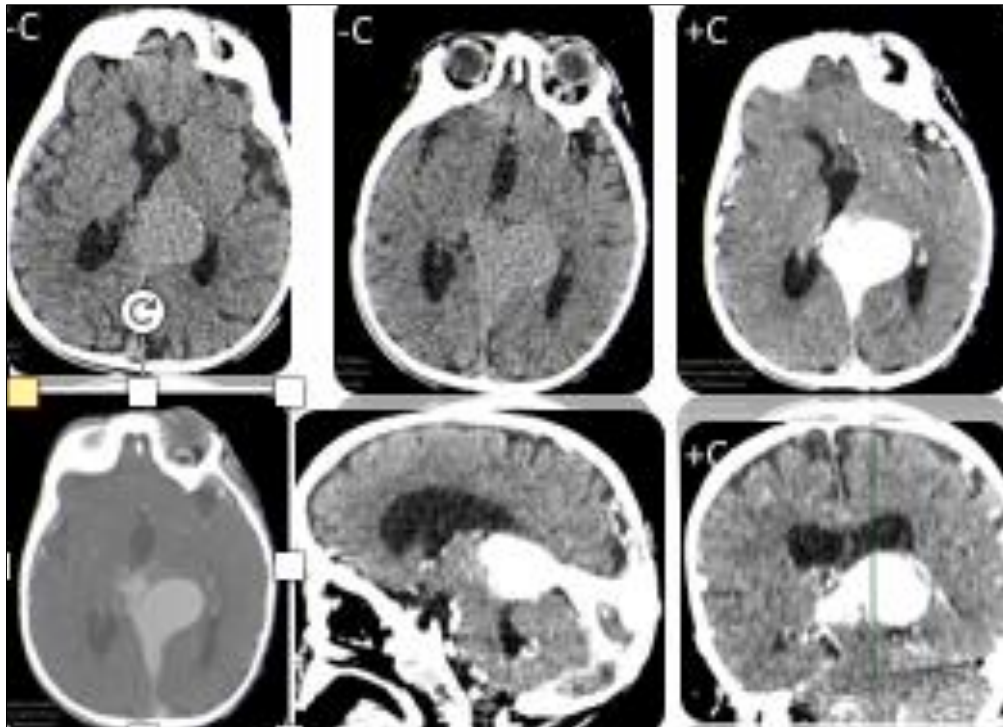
Brain CT in axial section and reconstructions Significant dilation of the vein of Galen spontaneously hyperdense, seat of fine peripheral calcifications, strongly enhancing after injection of PDC associated with multiple dilated vascular structures tortuous intraparenchymal cortical subcortical
